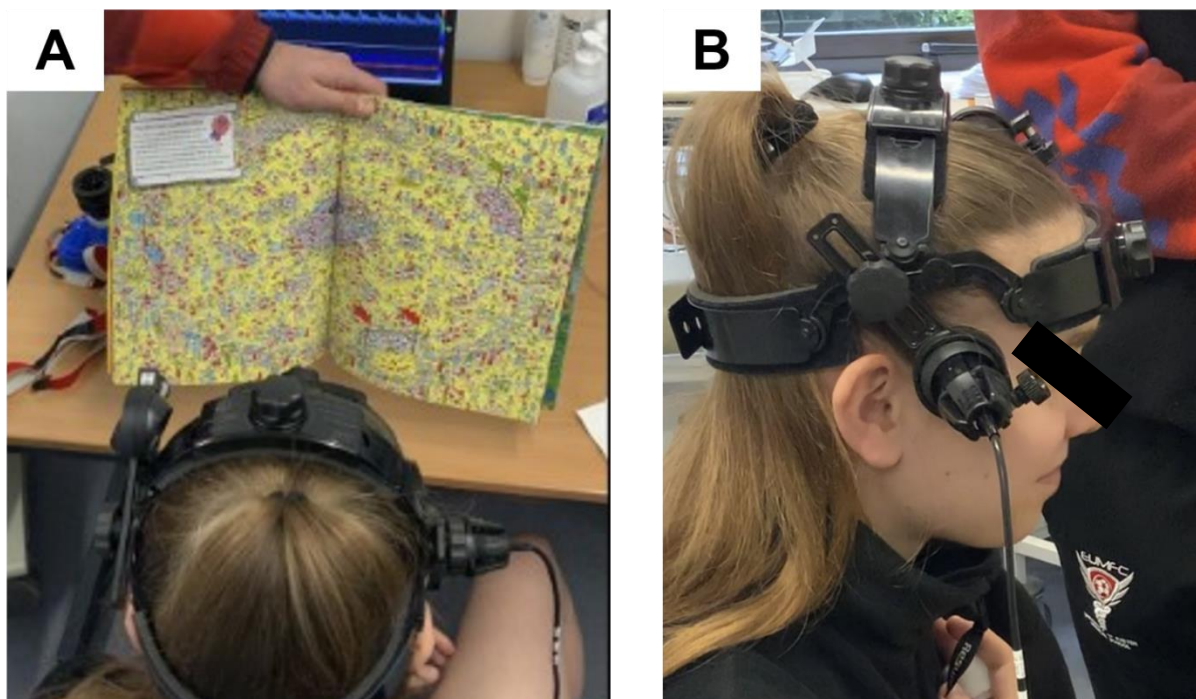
Example of experimental setup used to measure posterior cerebral artery blood velocity for neurovascular coupling assessment. A. Where's Wally search task displayed ~60cm in front of participants. B. A customisable headset was used to secure a 2-MHz ultrasound probe over the right temporal acoustic window.
